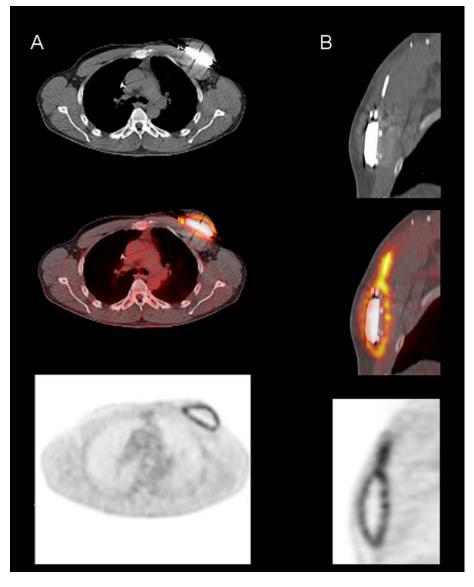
Pocket generator and lead infection in a patient with an automatic implantable defibrillator. Transverse (A) and sagittal (B) ¹⁸F-FDG PET/CT images. The device was removed. Both generator and lead cultures were positive for *Stahpylococcus aureus*.
